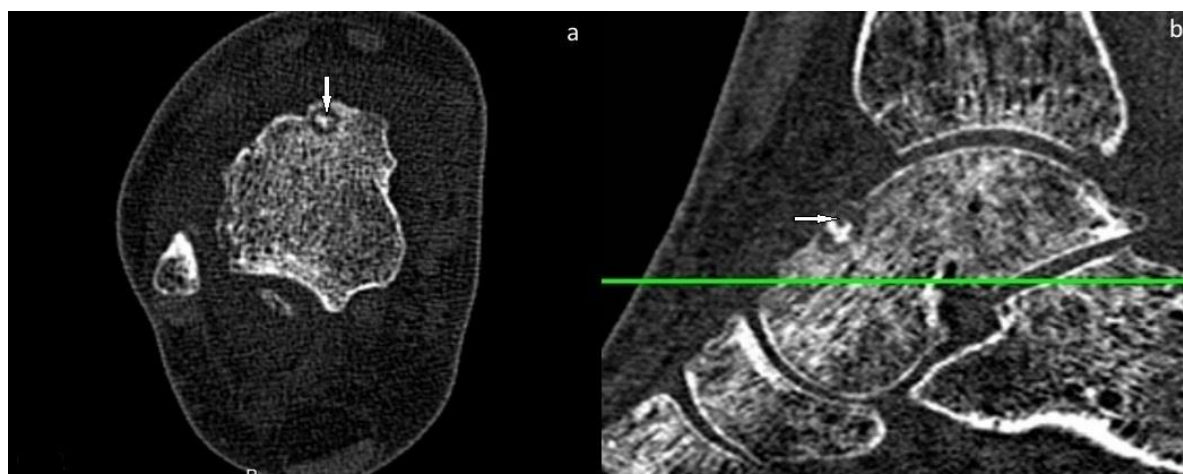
A 31-year-old female patient. Thin-slice, non-contrast (a) (axial), (b) (sagittal) reformatted CT images show no significant sclerosis in talus anterior and midline and the other joints in the ankle showed that the joint spaces were saved and joint surfaces were regular. CT—Computed Tomography.
